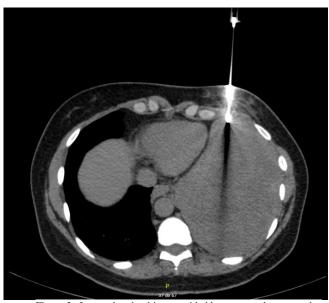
Image showing biopsy guided by computed tomography for percutaneous puncture.
